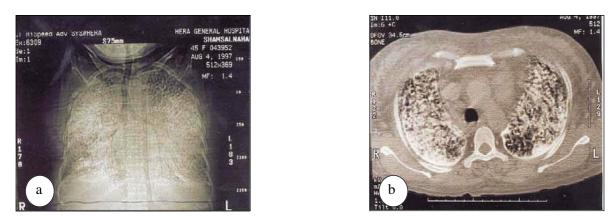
High resolution computed tomography scan through the lung of one millimeter thickness showing (a & b) Clear accentuation of reticular structures with dense miliary sized nodules clearly identifiable, causing nodular thickening of lobular septa.
